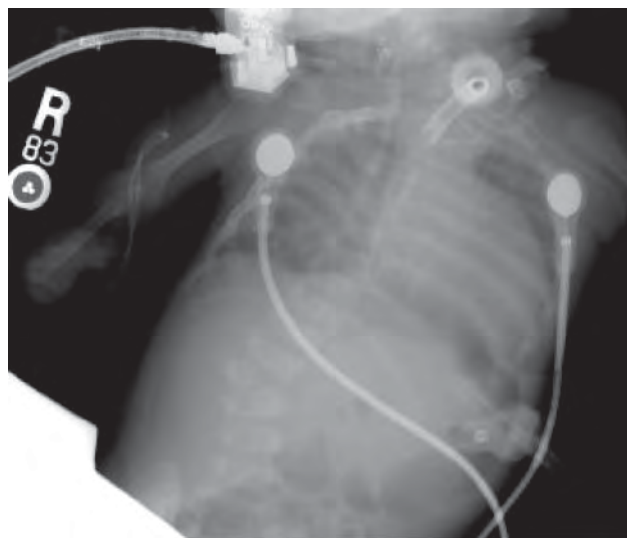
Frontal radiograph of the chest in a patient with repair of a prior tracheoesophageal fistula. Notice that there is cardiomegaly in this patient with a large atrial septal defect (ASD) and VSD. Also notice the hemivertebral body at L2 and the absent right radius. Patients with congenital disease heart often have associated anomalies that follow the VACTERL mnemonic.
